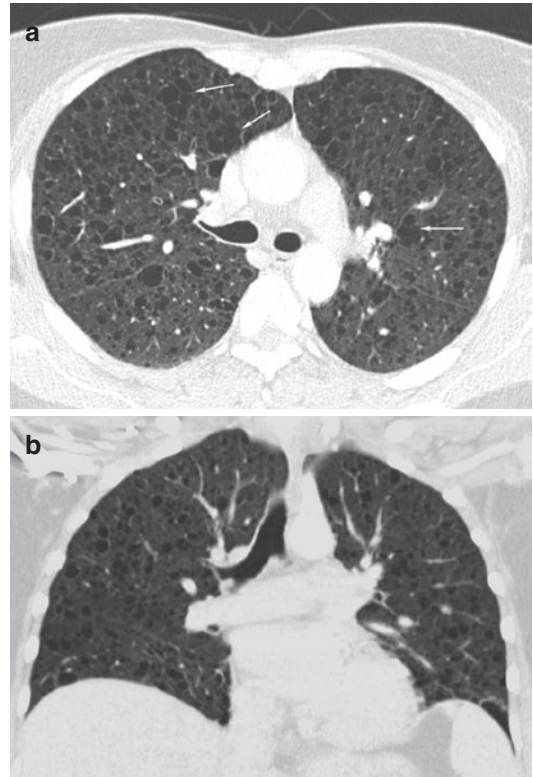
(a, b) 30-year-old woman with tuberous sclerosis complex. Axial CT image shows multiple thin-walled cysts in a uniform distribution. The cysts adjacent to the upper right mediastinum tend to conflate (white arrows) (a). Coronal CT image displays the uniform and bilateral distribution of the cysts throughout both lungs. The lung parenchyma between the cysts is inconspicuous (b)
